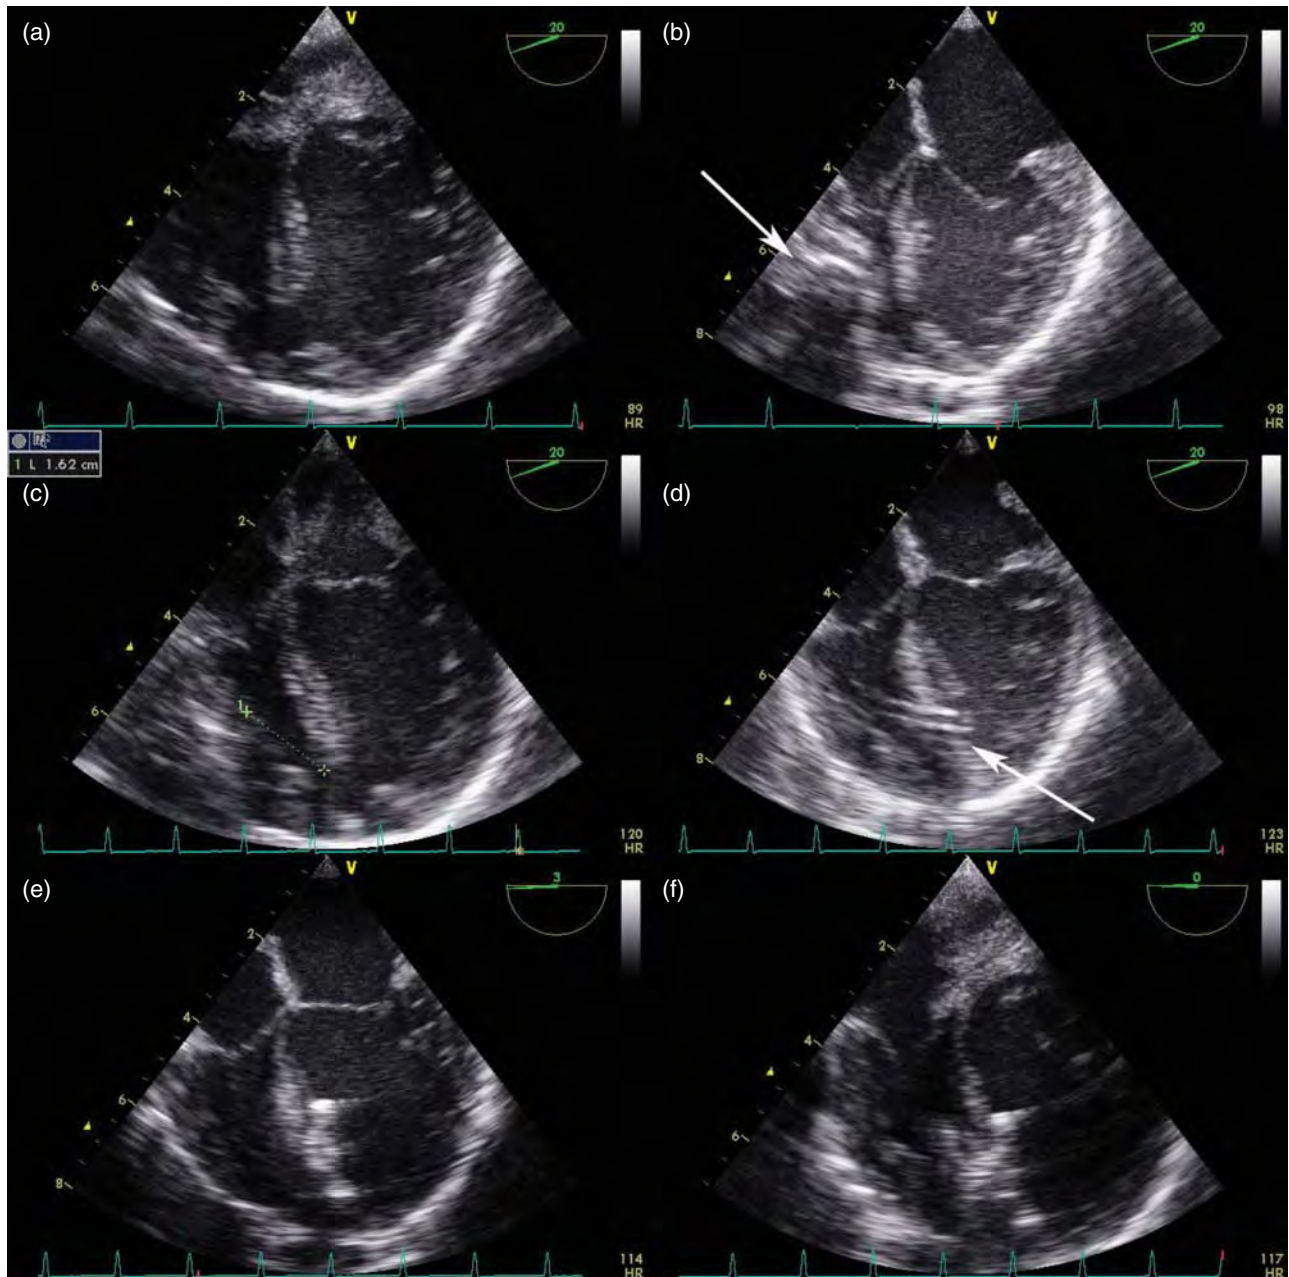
Perventricular closure of a muscular ventricular septal defect (VSD) in a 5-week-old infant. Once the RV free wall is exposed, the VSD is profiled (a) and the ideal access point to the VSD is determined using gentle manual pressure under transesophageal echocardiography guidance (b). This should be perpendicular to the VSD with sufficient distance between VSD and free wall to allow deployment of a device. The distance between RV free wall and VSD should be measured as to avoid advancing the sheath too far across the VSD (c). Once the access point has been chosen, a purse-string suture is placed and an 18 Gauge needle advanced through the purse string and directed towards the VSD. An 0.35 angled guidewire should be directed across the VSD under TEE guidance, followed by advancing a 7 Fr short sheath over the wire across the VSD, but not too far distally into the LV (d). The chosen device size should usually be about 2 mm larger than the size of the VSD. Its deployment is performed under TEE guidance where the device usually can readily be visualized crossing the sheath. The LV disk should be deployed just distal to the ventricular septum (e), taking care not to push the device against the LV free wall, or to entangle the mitral valve apparatus. This is followed by deploying the RV disk, and releasing the device after echocardiography confirmed an accurate device position as well as absence of interference with AV valves (f).
